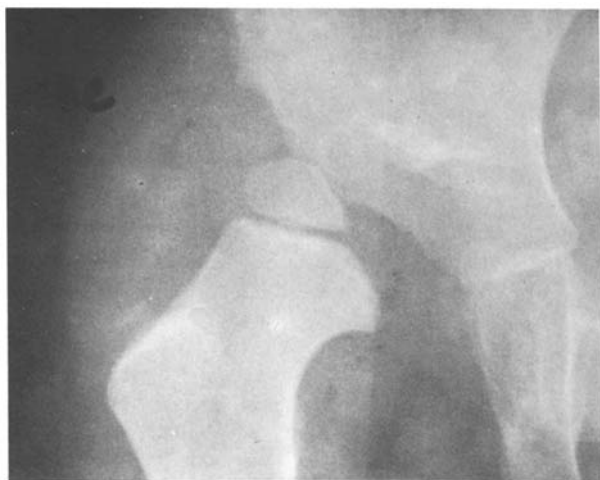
Radiograph to 7a-d
